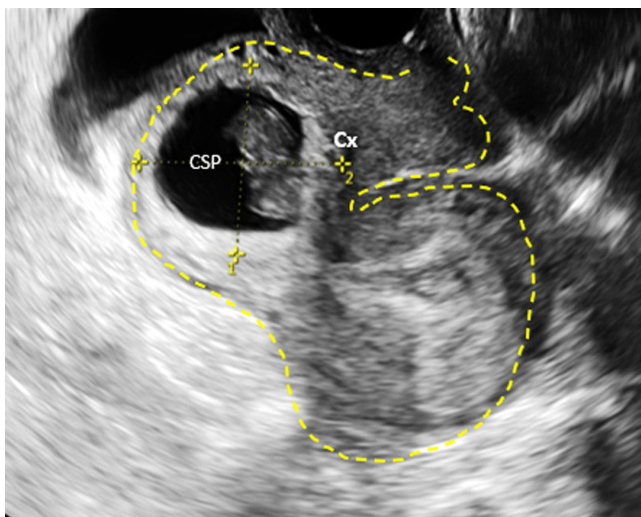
Grayscale ultrasound image of Cesarean scar pregnancy (CSP) at 9 + 5 weeks' gestation in anteverted retroflexed uterus (dashed line) with practically no measurable residual myometrial thickness. Cervix (Cx) is in anteverted position while uterine body with its empty cavity is retroflexed. No intervening myometrium is seen between decidua of gestational sac and bladder.
